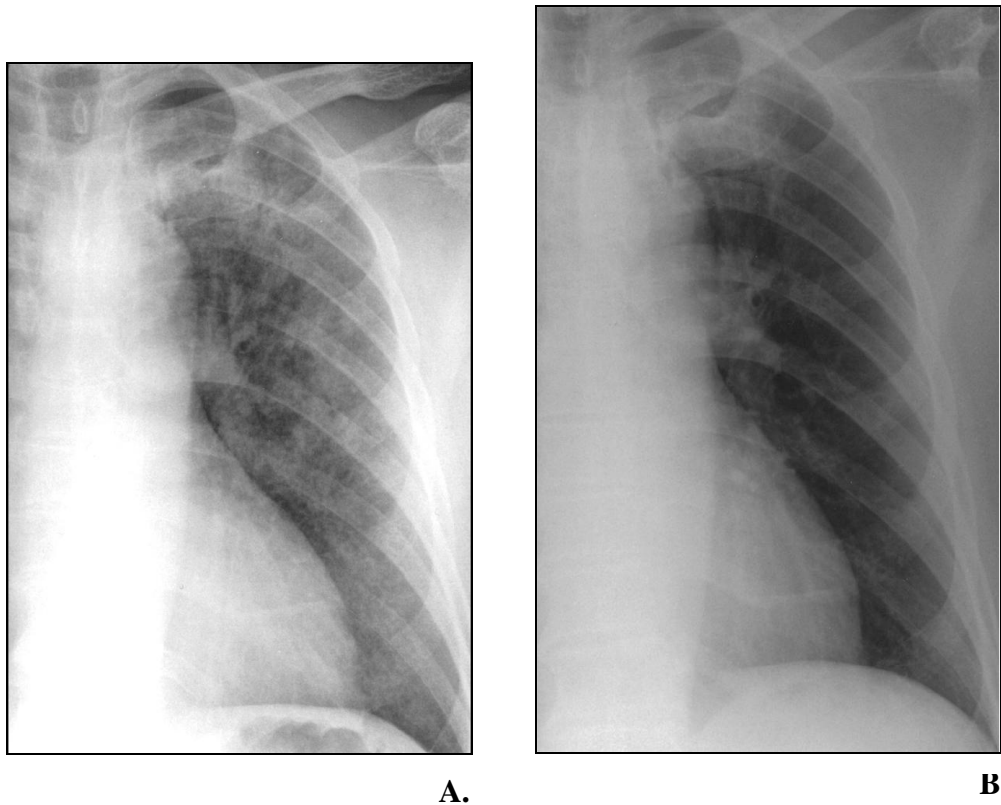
59-year-old man who presented with fever, dyspnea and chest pain. (A) Initial chest radiograph shows ground-glass attenuation in left upper, middle and lower lung zones. (B) Chest radiograph obtained 4 days after initial film. Left middle and lower lung zones have cleared and residual ground-glass attenuation is noted in left upper lung zone.
